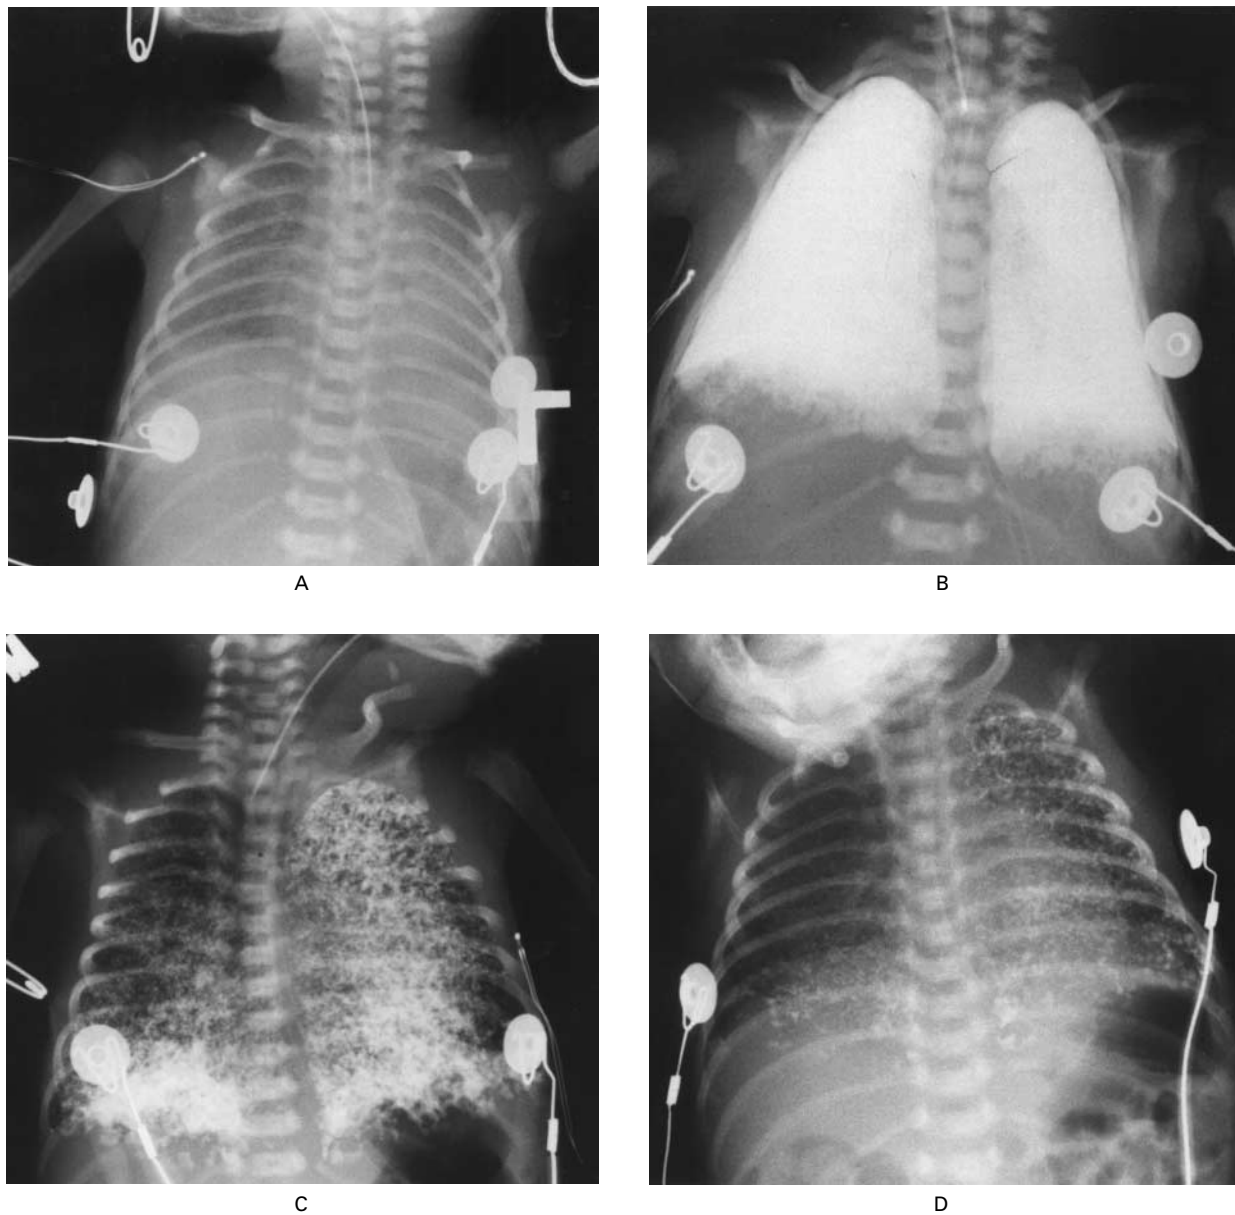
Chest Radiographs in One Infant during Treatment with Gas Ventilation (Panel A), 1 Hour after the Initiation of Partial Liquid Ventilation with Perflubron (Panel B), and 48 Hours (Panel C) and 3 Weeks (Panel D) after the Last Dose of Perflubron.
